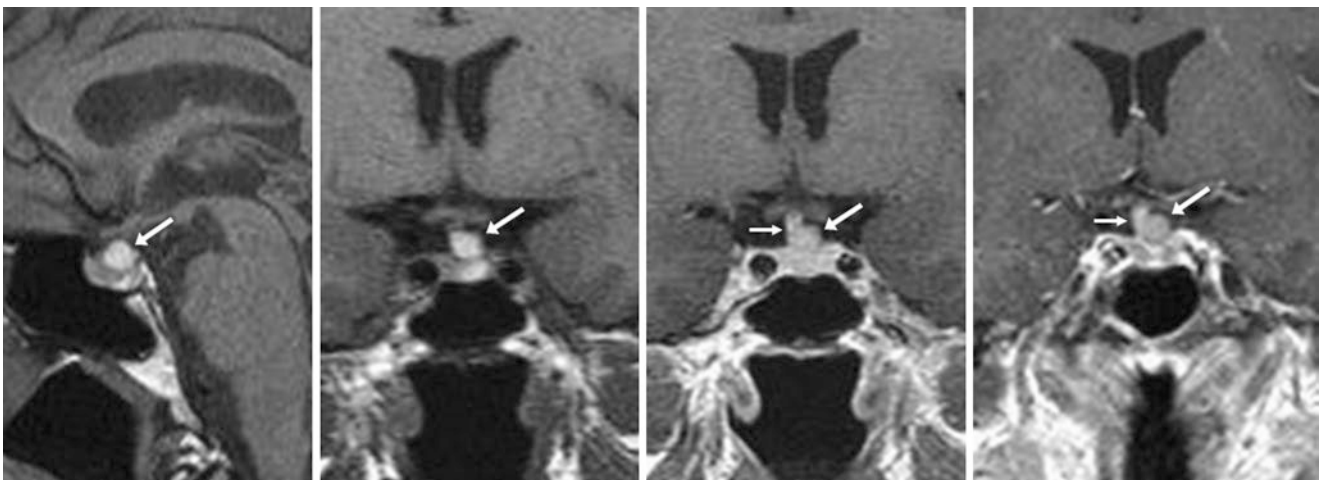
The patient was a 61-year-old female with stroke-like symptoms lacking pituitary symptoms. A 1.5 T MRI demonstrated a 7-mm T1-bright RCC (arrows) superiorly along the gland and to the left of the stalk (thin arrows) on noncontrast sagittal T1WI (left) and coronal T1WI (left middle) with intensity similar to the rest of the gland postcontrast coronal T1WI (right middle). A repeat postcontrast T1WI (right) did not demonstrate any significant change several months later
